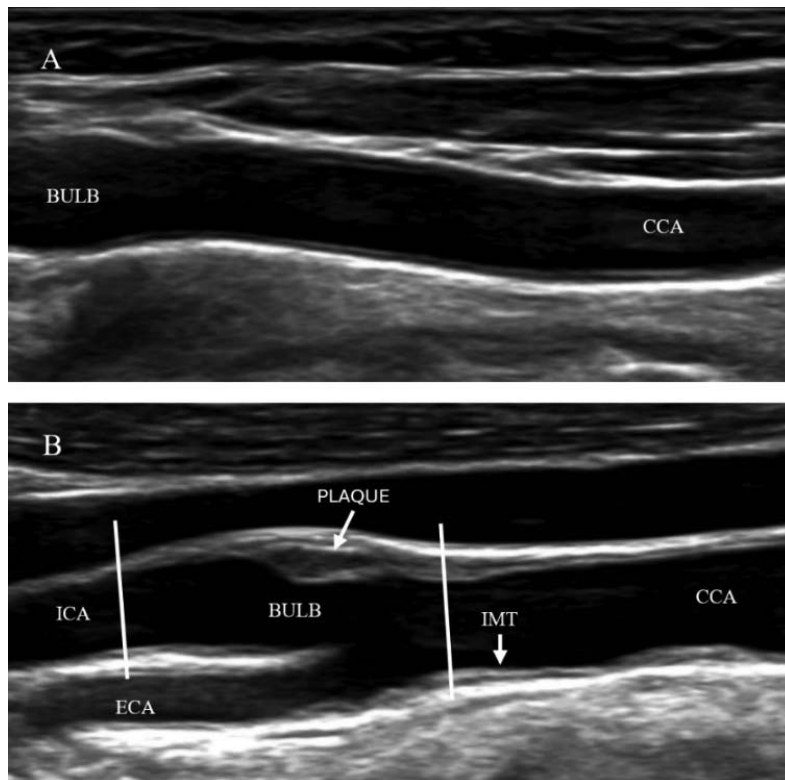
Carotid artery ultrasound with IMT measurement.
